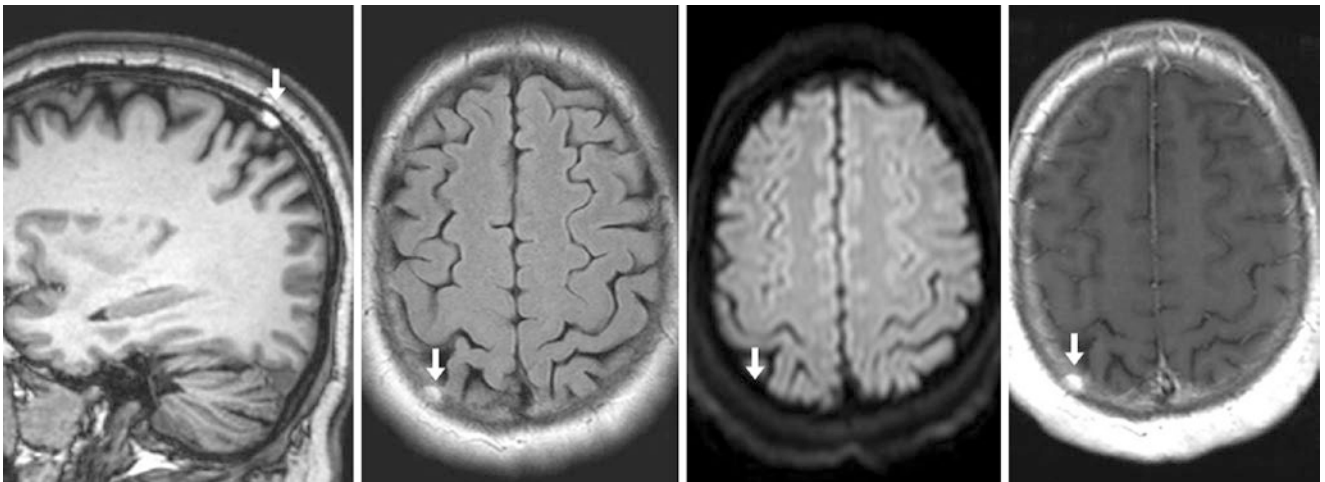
A 76 year old in whom a focal T1-bright lesion within the right parietal calvarium was noted on sagittal T1WI (*left*) and FLAIR (*left middle*). This lipoma was dark on DWI (*right middle*) and retained
